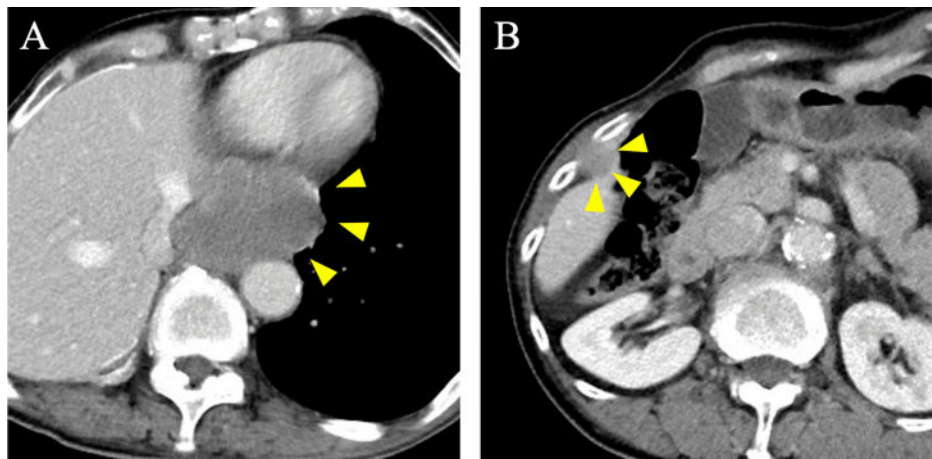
Chest computed tomography (CT) findings at disease progression before nivolumab initiation.
